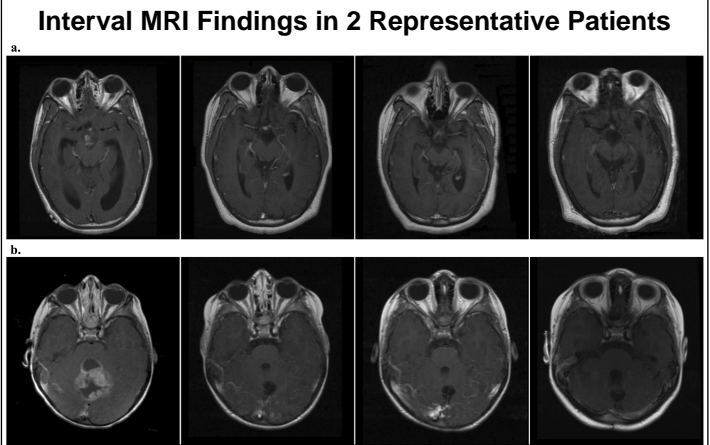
a. Consecutive long-term follow up of hypothalamic juvenile pilocytic astrocytoma resected subtotally as seen on contrasted MRI preoperatively, at 12 months, 48 months and 96 months from left-to-right (Patient 10); b. Consecutive short-term follow up of vermian juvenile pilocytic astrocytoma resected gross totally as seen on contrasted MRI preoperatively, at 3 months, 9 months and 30 months from left-to-right (Patient 6).
